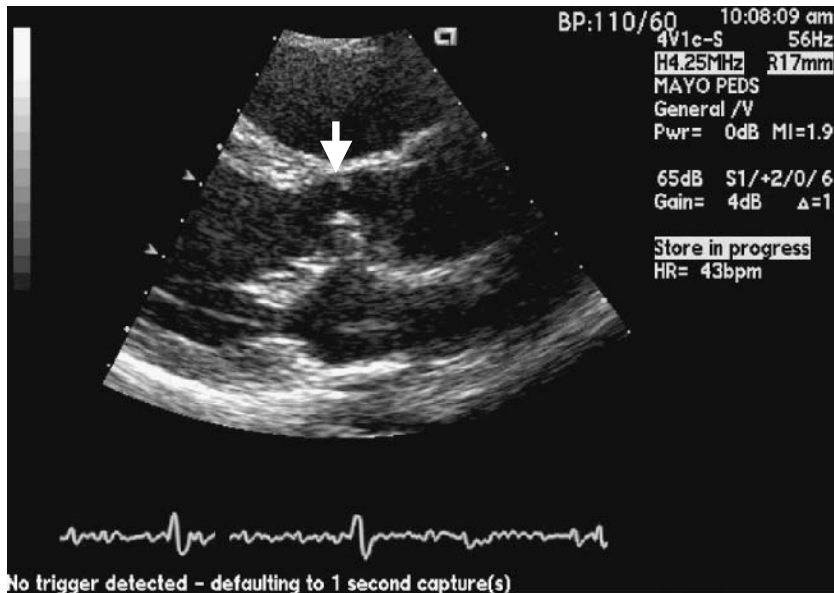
Parasternal long axis projection demonstrating a subaortic membrane (arrow) that developed in a teenager, 15 years after repair of partial AVSD.
